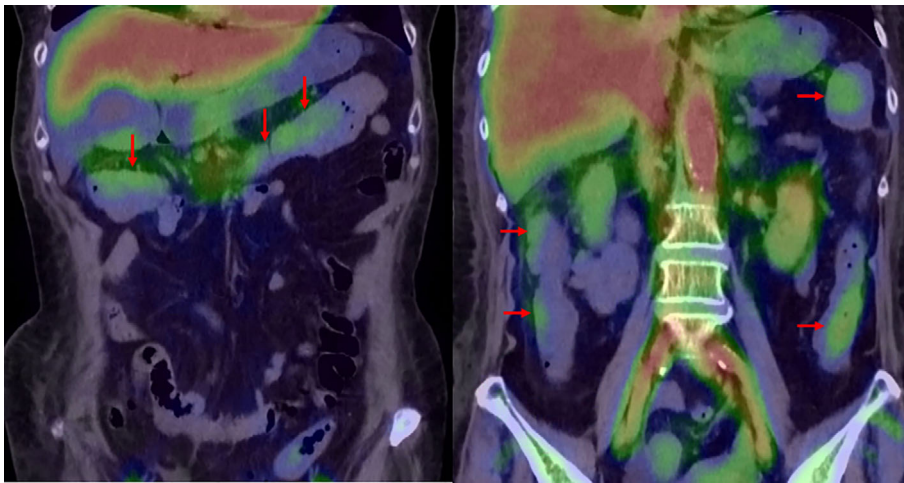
Protein leakage scintigraphy using  $^{99m}\text{Tc}$ -HSAD
